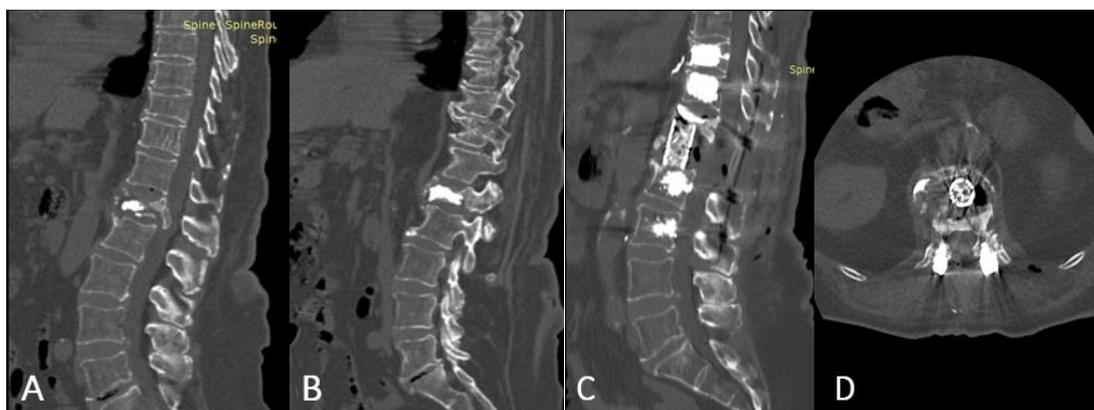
Preoperative CT images demonstrating a type A3 compression fracture of the L1 vertebral body with spinal cord compression (A, B). Postoperative CT scans obtained on postoperative day 1 (C, D)
